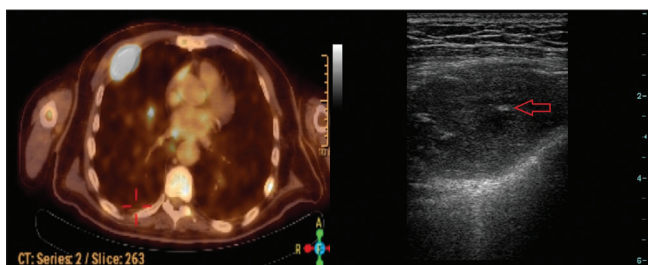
Hypermetabolic lesion in the dimensions of 5 cm × 3 cm in the chest wall on the right hemithorax. Ultrasonographically in approximate dimensions of 5 cm × 3 cm, irregular margin hypoechoic lesion
